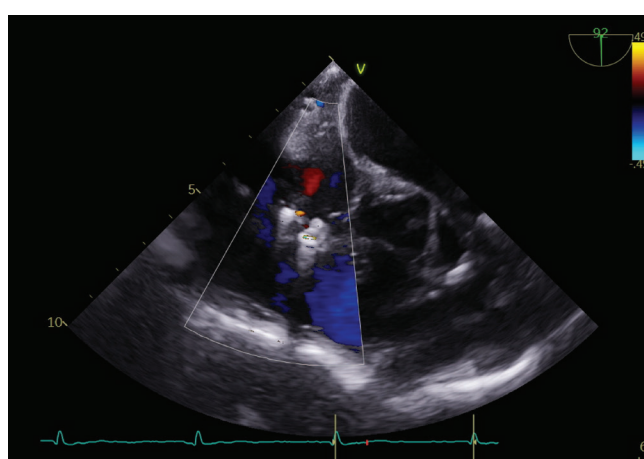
Transesophageal echocardiography showing reduction of tricuspid regurgitation to trivial levels after transcatheter edge-to-edge repair using two cobalt-chromium clips [TriClip XTWx2].
